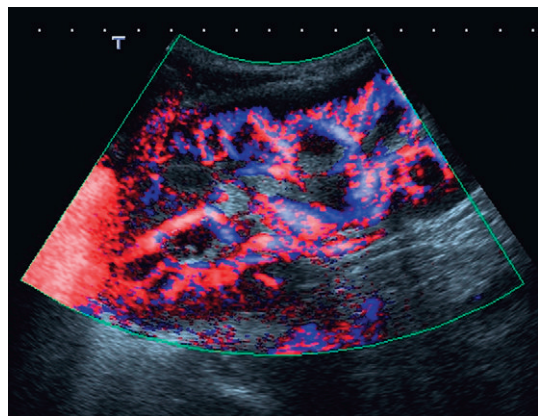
Greater sensitivity of colour flow Doppler affords directional information as well as identification of the interlobular arteries.
